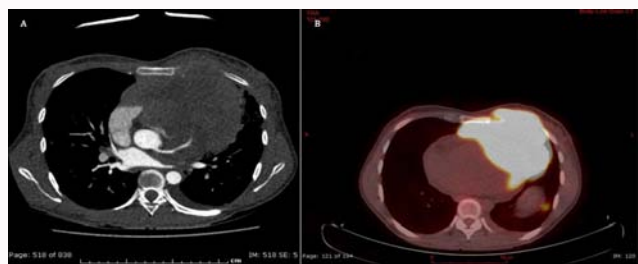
Initial imaging performed before any treatment attempted. A) Aortic CECT (Contrast-Enhanced CT-scan) shows a large heterogeneous invasive anterior mediastinal mass with pleural, anterior chest wall and pericardial invasion. Moreover, there is soft tissue infiltration surrounding the left coronary artery with wall irregularities; B) FDG-PET (Fluoro Desoxy Glucose-Positron Emission Tomography) scan shows the large hypermetabolic (SUV: 17) anterior mediastinal mass with evidence of chest wall & pericardial invasion.
